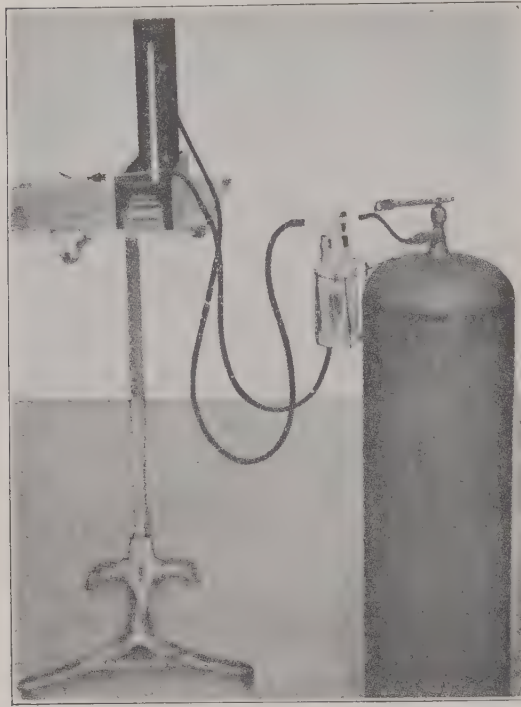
Older apparatus for insufflating gas through fallopian tubes. (Rubin—*Am. Jour. Roentgenology*.)
